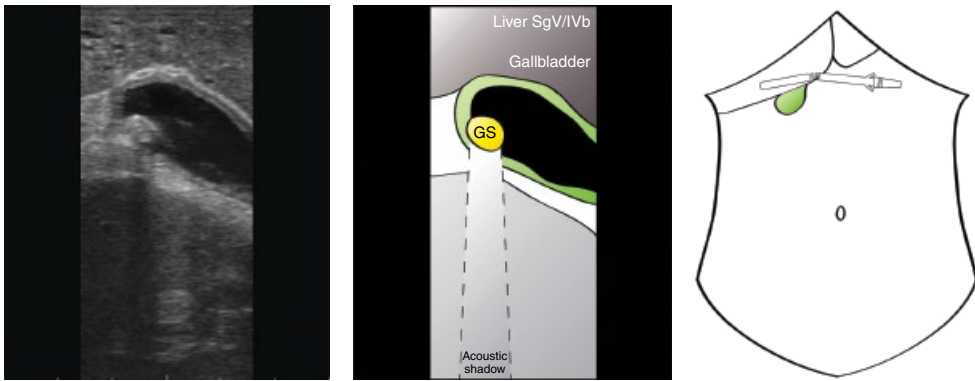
Laparoscopic ultrasonographic evaluation of benign biliary disease. In this example, the correct positioning of the laparoscopic ultrasound probe is demonstrated to identify the obvious gallstone (GS).
